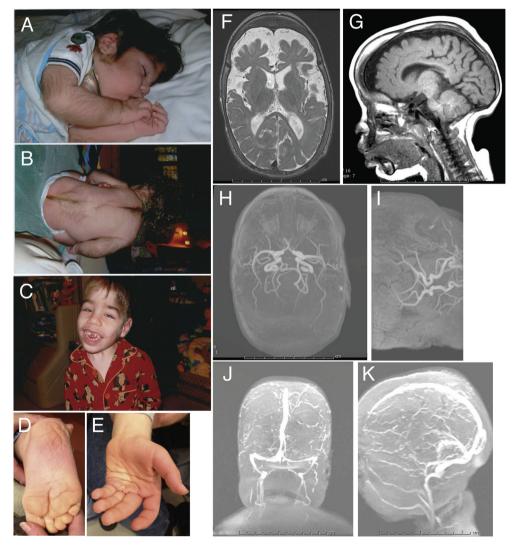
Clinical phenotype of the patient. Shown are photographs of the patient, (A–B) when an infant, (A) face and right arm, (B) his back, and (C–E) his recent pictures (C) his face, (D) palm and (E) sole. His (F–K) MRI imaging of the brain at 8 months of age is also shown, specifically, (F) axial T-2 weighted, (G) sagittal T-1 weighted, (H–I), MR angiography, and (J–K) MR venography. Note the hypertrichosis, short neck (A–B) and coarse facial features including bulbous nose, prominent mouth, thick lips and gingival hyperplasia with irregular teeth (C). Deep palmar and plantar creases with wrinkled skin and thickened pads on palms and soles are also seen (D–E). MRI findings include cerebral atrophy (F–G), thick calvarium (G), thin corpus callosum (G), tortuous circle of Willis (H) and internal carotids (I), multiple tortuous venous collaterals and no flow in the inferior sagittal sinus.
